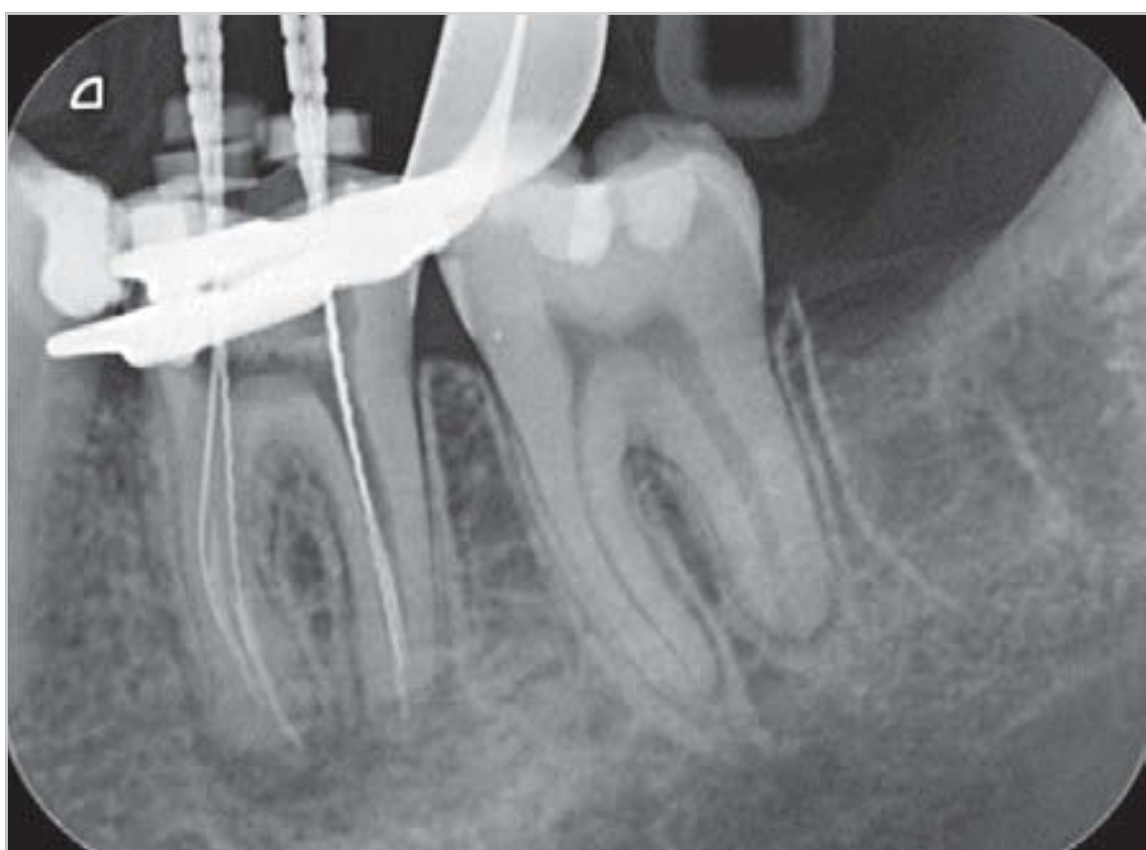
Radiographic measurement of the working length of a root canal.
